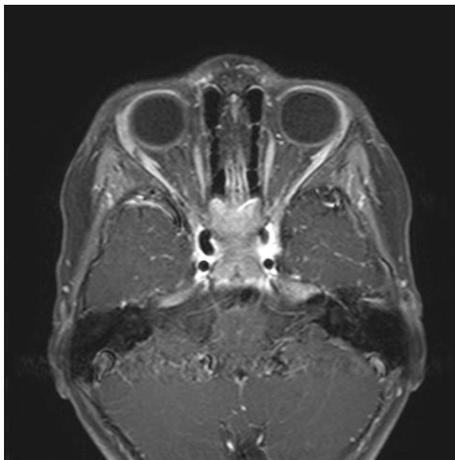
Patient 7. Axial T1-weighted, gadolinium-enhanced brain MRI showing enhancement of bilateral abducens nerves (arrows).
